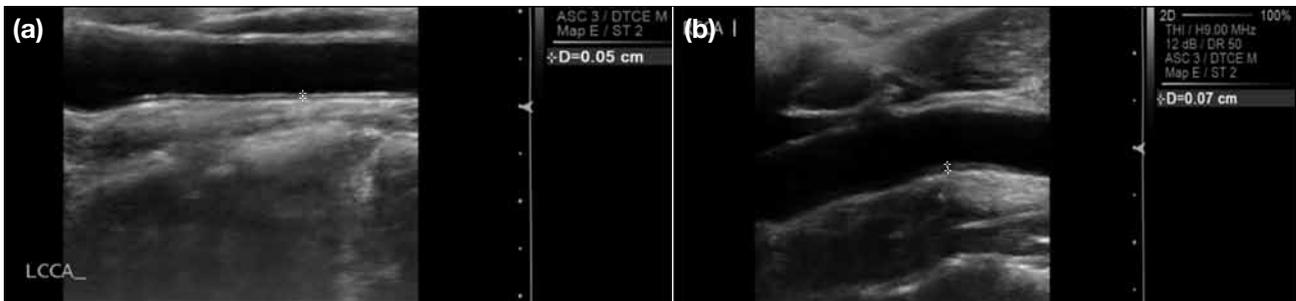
Ultrasonography showing the carotid intima-media thickness of the (a) left and (b) right common carotid arteries (outlined by callipers).
